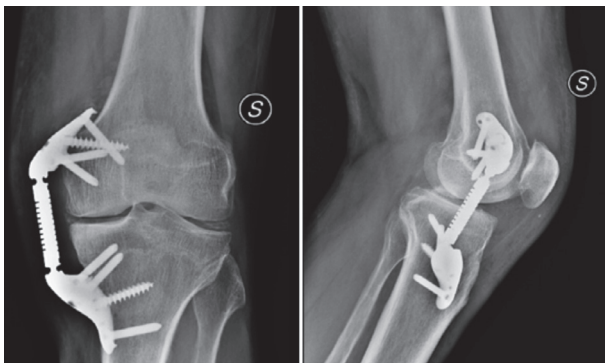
Radiographs of the left knee showing Kinespring system installation
